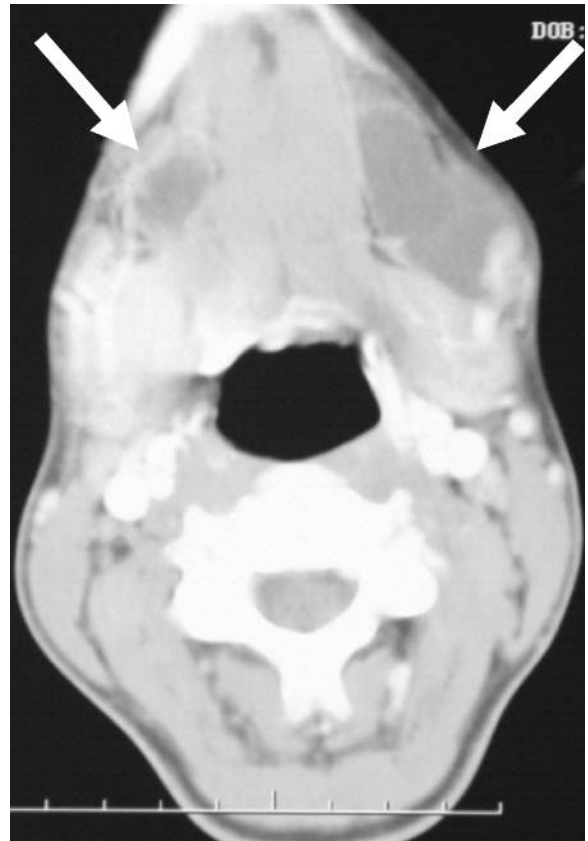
Axial view contrast-enhanced CT scan of bilateral plunging ranula
